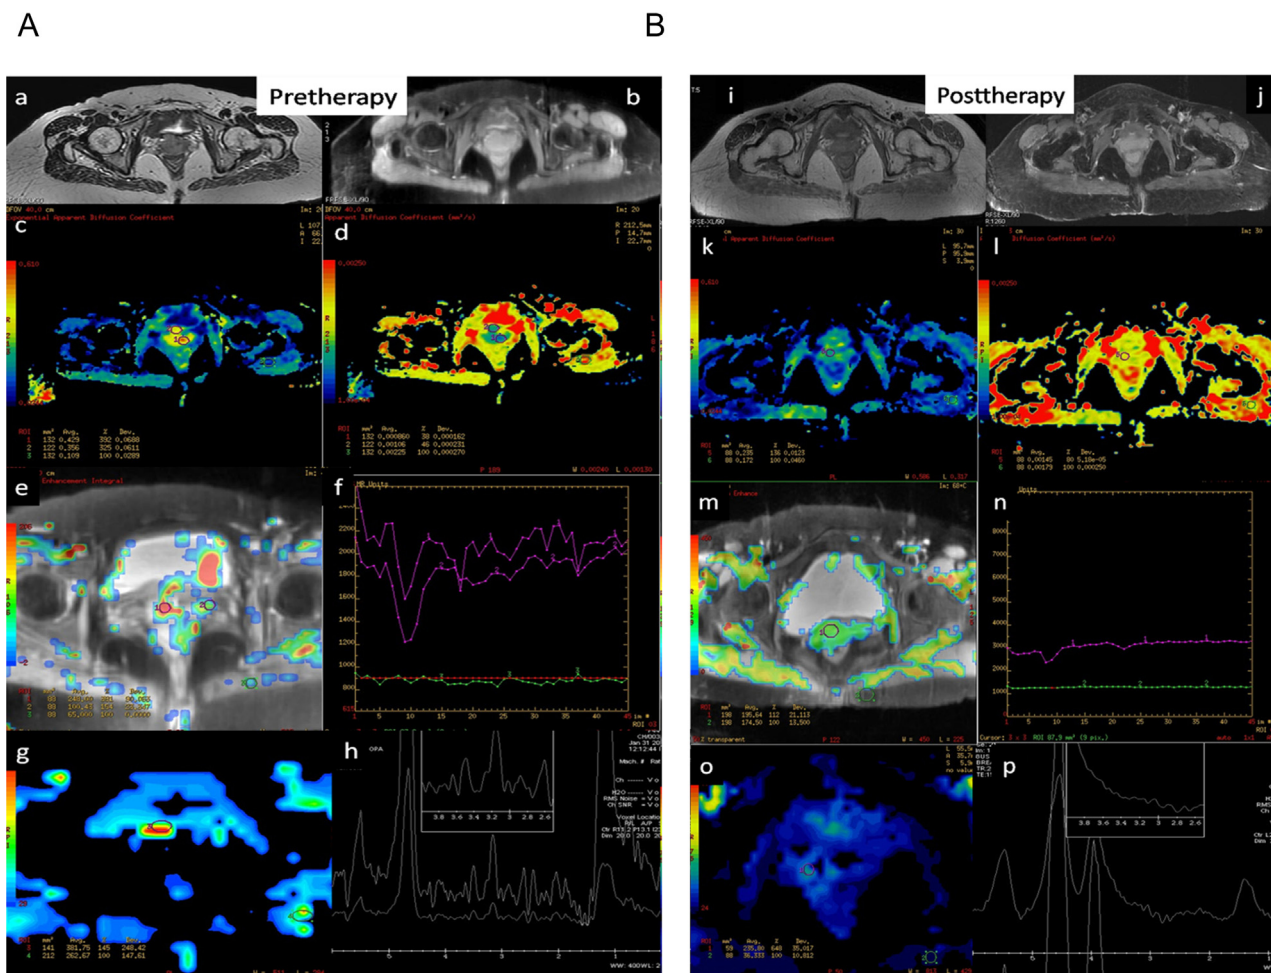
(A and B). Case 3: Conventional and MPMRI in a case of vault recurrence: pre and post therapy imaging findings. Conventional and MPMRI comparison showed that there was a mild interval regression of tumor volume with no significant change in the enhancement (a, b and i, j). On DWI images there was interval regression on the restricted component with significant increase in the ADC values (c, d and k, l). On DCE-MRI there is a significant regression of the perfusion with a significant decrease in the slope of enhancement (e, f and m, n). On BOLD sequence there was a small central core of hypoxia which on follow up showed significant regression in the chronic hypoxic fractions and near normal oxygenation (g and o). On MRS the choline peak noted at 3.2 peak was absent in the follow up MRS (h and p). All these findings were suggestive of response to therapy, predicted at the molecular level with not much change in the morphology of the lesion.
